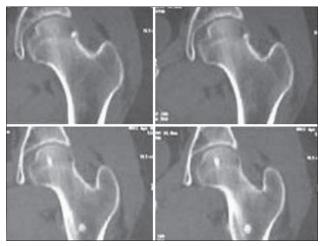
Computed tomography (CT) scan shows four distinct nidus in proximal femur
